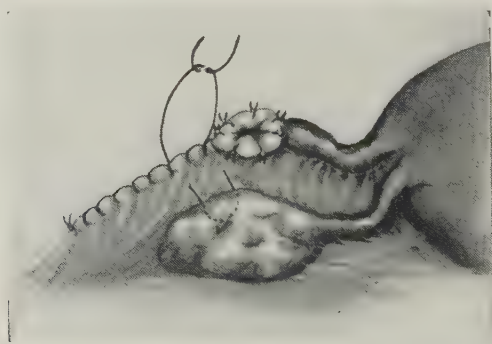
TERMINOLATERAL SALPINGOSTOMY FOLLOWING PARTIAL SALPINGECTOMY OF THE OUTER ASPECT OF THE TUBE \_ AND FOLLOWED BY OÖPHOROPEXY OF THE OVARY TO THE ADJACENT MESOSALPINX.
